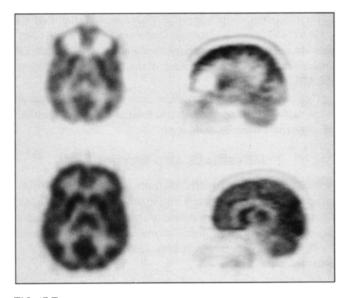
Effect of having emission and transmission data not spatially aligned. The top two images show the appearance of hypometabolism in the frontal lobe region due to improper alignment of the transmission and emission sinograms. The misalignment between the sinograms was corrected and the data were reconstructed. Radiotracer uptake distribution is typical of a normal FDG brain image, as seen in the bottom two images.
